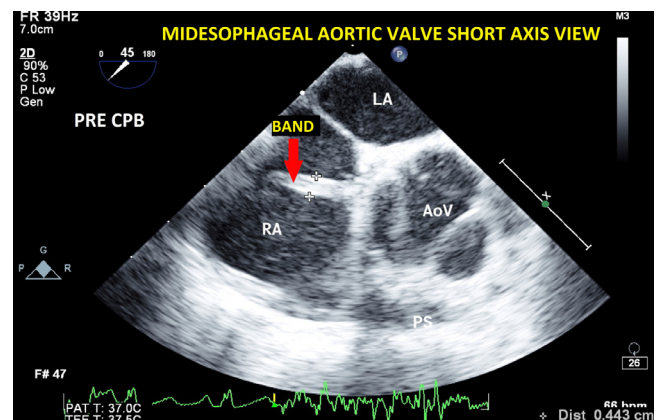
Pre-cardiopulmonary bypass transesophageal echocardiographic examination in the midesophageal aortic valve short-axis view showing the long axis of the band in the right atrium (red arrow) with a thickness of about 4.4 mm. AoV, aortic valve; CPB, cardiopulmonary bypass; LA, left atrium; PS, pulmonary stenosis.
